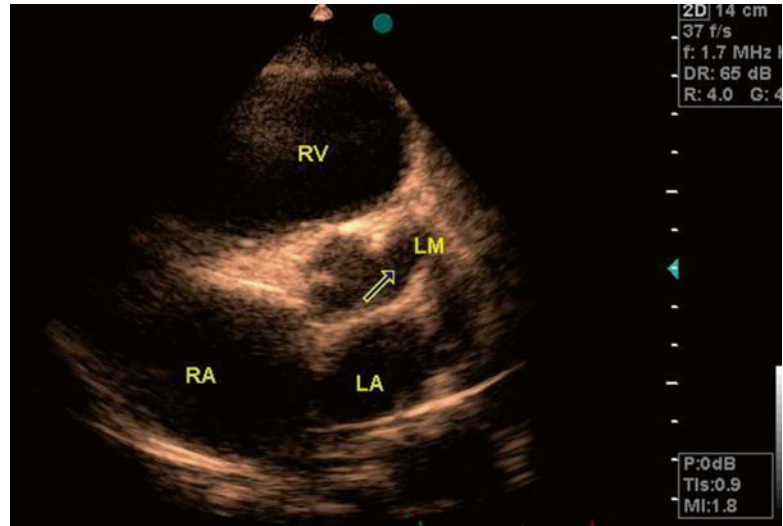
(a–c) Off-axis transthoracic echocardiography showing coronary artery fistulae with aneurysmal formation and continuous turbulent flow which drains to the right
